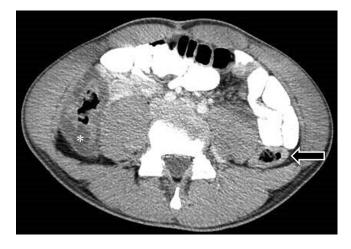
Axial CT image with intravenous and enteric contrast shows thickening of the cecum/ascending colonic wall (*asterisk*) and to a lesser degree the descending colonic wall (*arrow*) in this adolescent patient with colitis.
